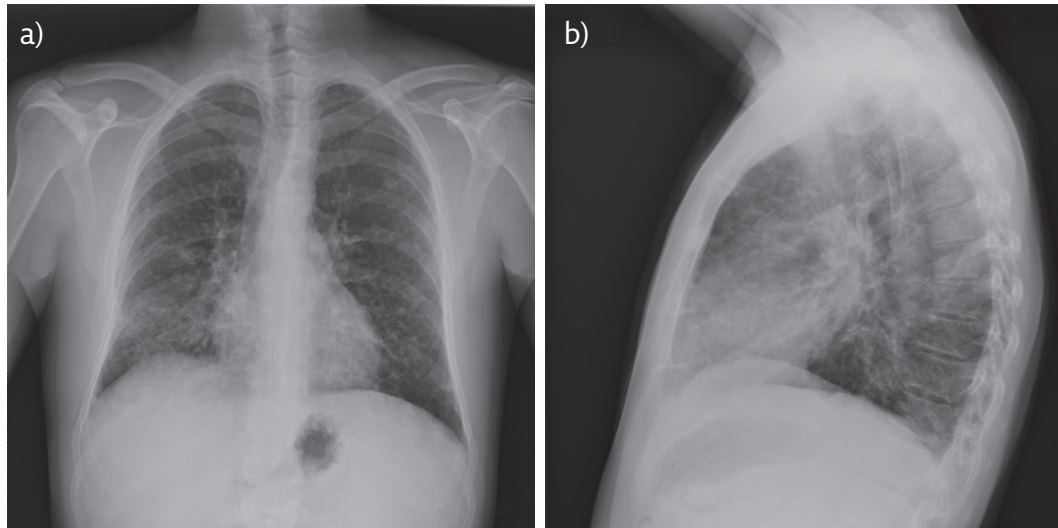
a) Posteroanterior and b) lateral chest radiography showing a diffuse reticulonodular pattern with slight apico-basal gradient and normal cardiac silhouette.
